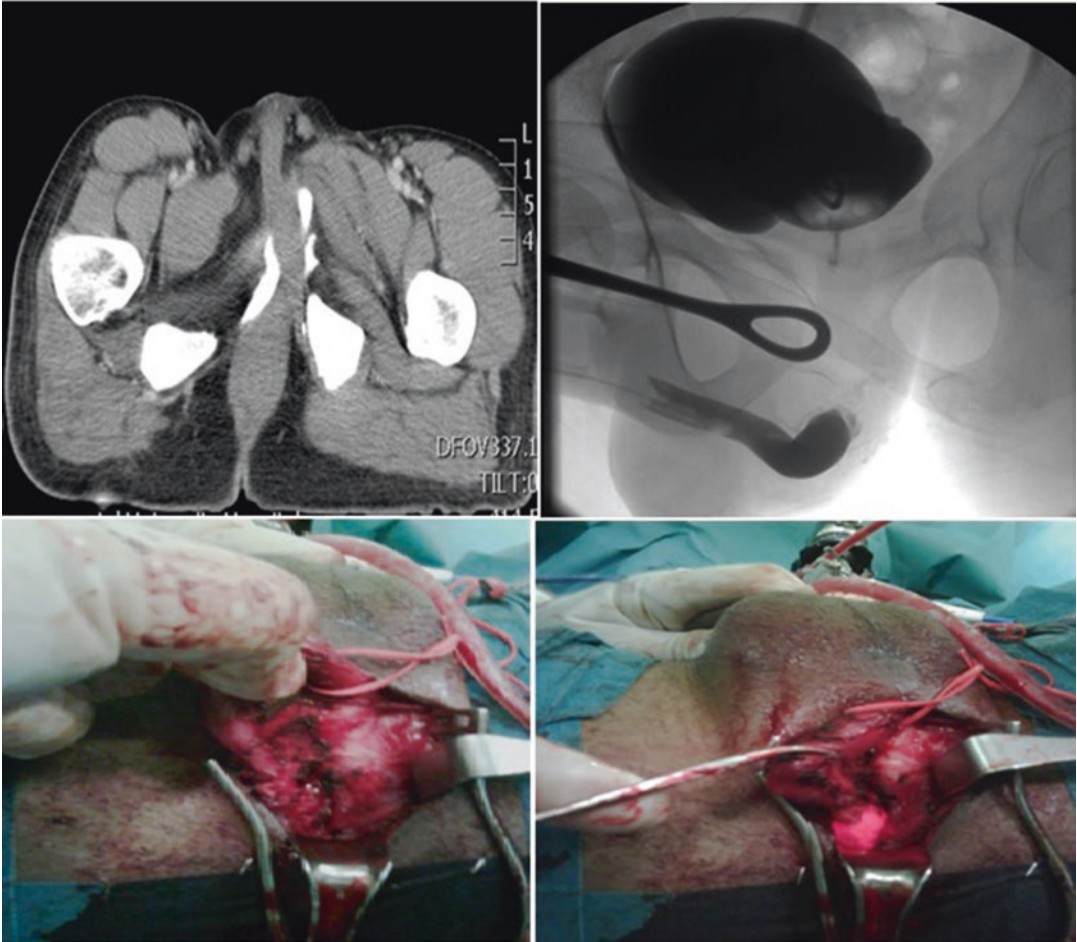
CT scan demonstrates pelvic fracture-associated posterior urethral disruption. Cystogram and retrograde pyelogram were done to delineate the location
